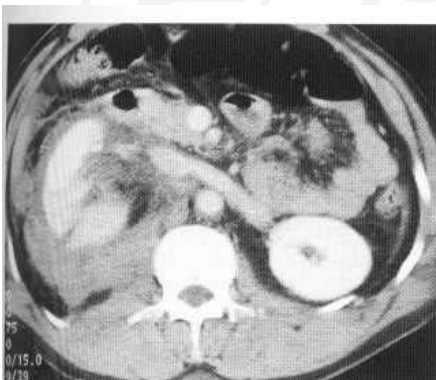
Contrast CT showing a fracture through the centre of the kidney with considerable circumferential perinephric haemorrhage (A). Two months after conservative management there has been impressive healing of the kidney and resorption of most of the haemorrhage (B).
